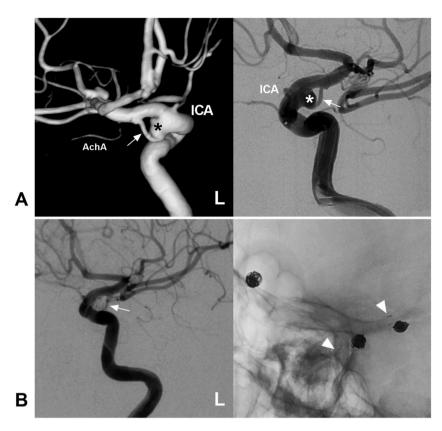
EVT of supraclinoid ICA fenestration aneurysm. A: Three-dimensional DSA (left panel) and two-dimensional DSA (right panel) of the left ICA showing fenestration (arrows) at a supraclinoid ICA with an aneurysm (asterisks). The upper limb is thick, and the lower limb is thin. B: Left panel: DSA of the left ICA showing coiling of the aneurysm and preservation of the lower limb (arrow); Right panel: X-ray image showing the markers (arrowheads) of the stent to assist coiling.
